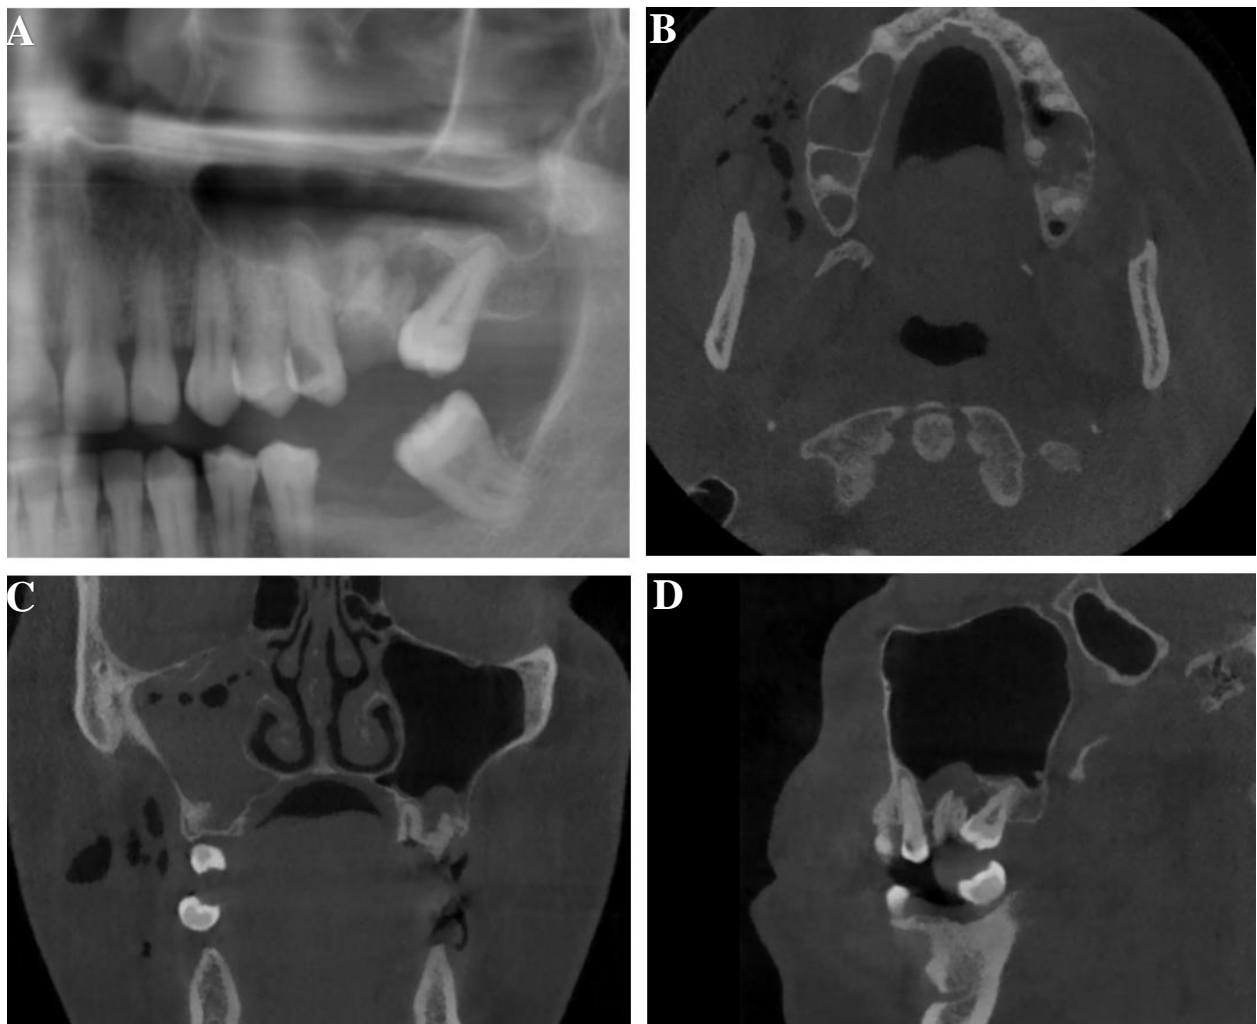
ROI tooth 28. A, cropped PAN depicting a well-defined, corticated, periapical radiolucency at carious tooth 28 causing elevation of the maxillary sinus floor. Partial opacification of the maxillary sinus is observed. CBCT slices: B, axial, C, coronal, and D, sagittal view. Showing a well-defined periapical low-density with breaching of the maxillary sinus floor. Mucosal reaction in the left maxillary sinus can be observed.
